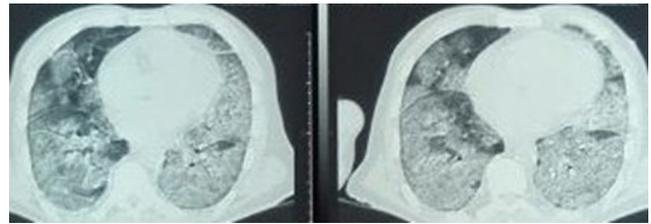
axial CT images show diffuse consolidation affecting the both lungs with Halo sign noted at the left lung.
